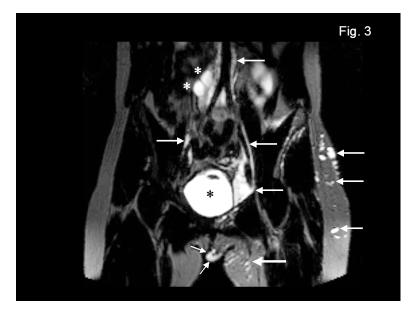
Coronal heavily T2-weighted 3D-TSE source image depicts multiple lymphangiomatous changes in the left subcutaneous tissue and pelvic region extending to the retroperitoneal space (arrows). At the level of the aortic bifurcation two cystic lymphangiomas are revealed on the right side (asterisks). Corresponding to the clinically observed vaginal lymphorrhea, lymphangiomatous changes are demonstrated in the left groin (large arrow) with extension into the genital region and thickened, fluid-filled labia on the left side (small arrows).
